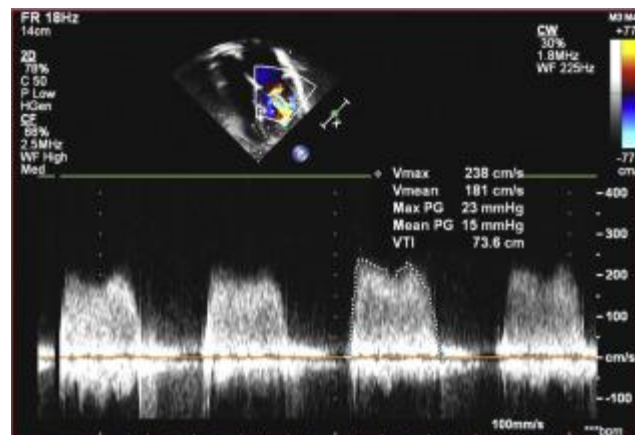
14.Measurement of Mean Pressure gradient using CW Doppler
